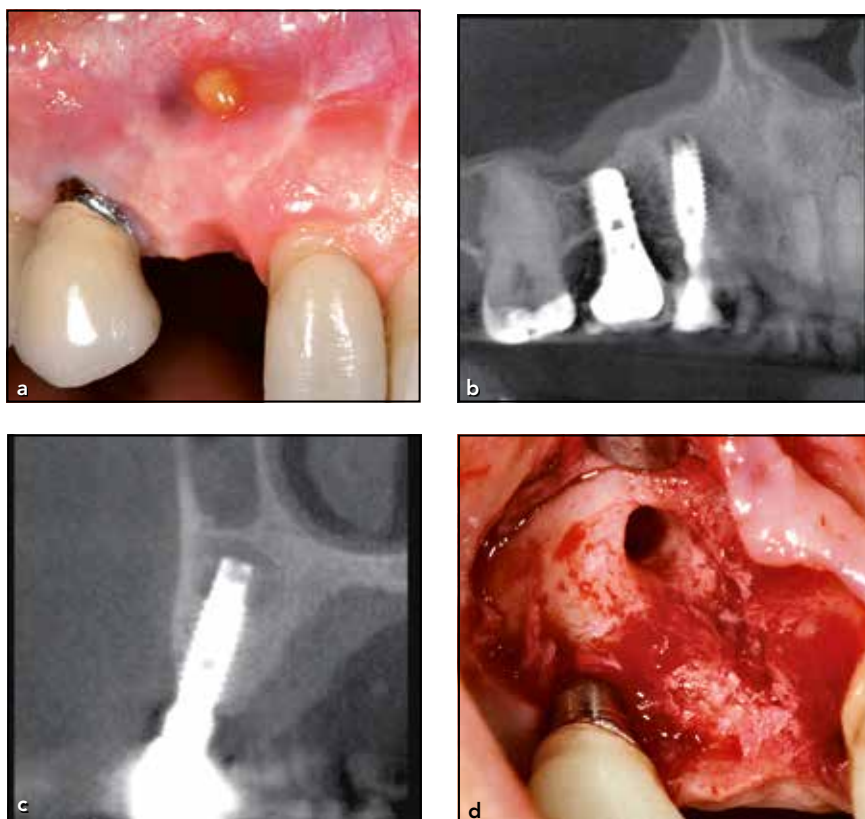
(a) A fistula was still present after tooth extraction. (b and c) CBCT sections of the right maxilla, confirming an intact sinus floor and an area of radiolucency around the most apical part of the implant. (d) First access surgery. The bone cavity was debrided, and the implant surface was decontaminated.
